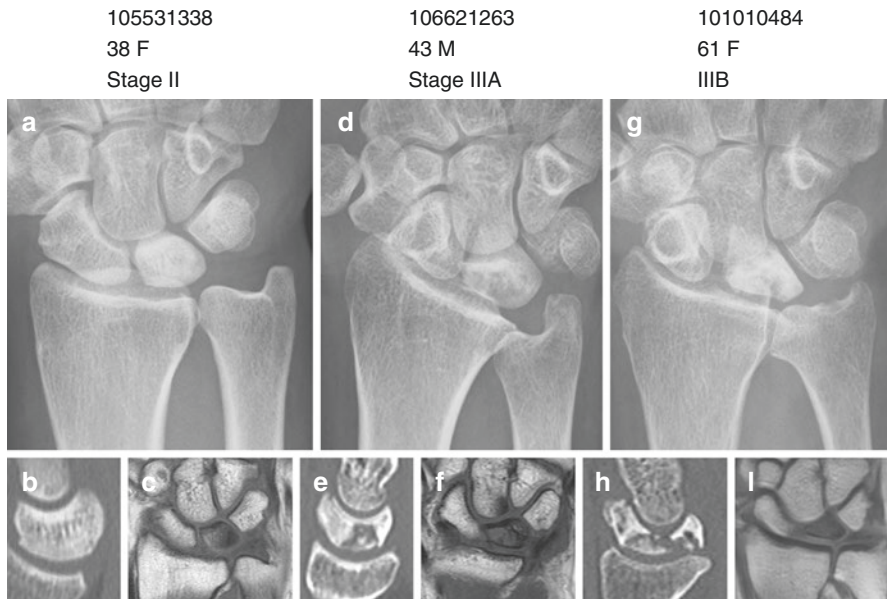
Typical imaging findings of Kienböck's disease. (a–c) A 38-year-old woman with stage II disease. (d–f) A 43-year-old man with stage IIIA disease. (g–i) A 61-year-old woman with stage IIIB disease. (a, d, g) plain radiographs. (b, e, h) Sagittal reconstruction views of computed tomography. (c, f, i) T1-weighted images of magnetic resonance imaging
